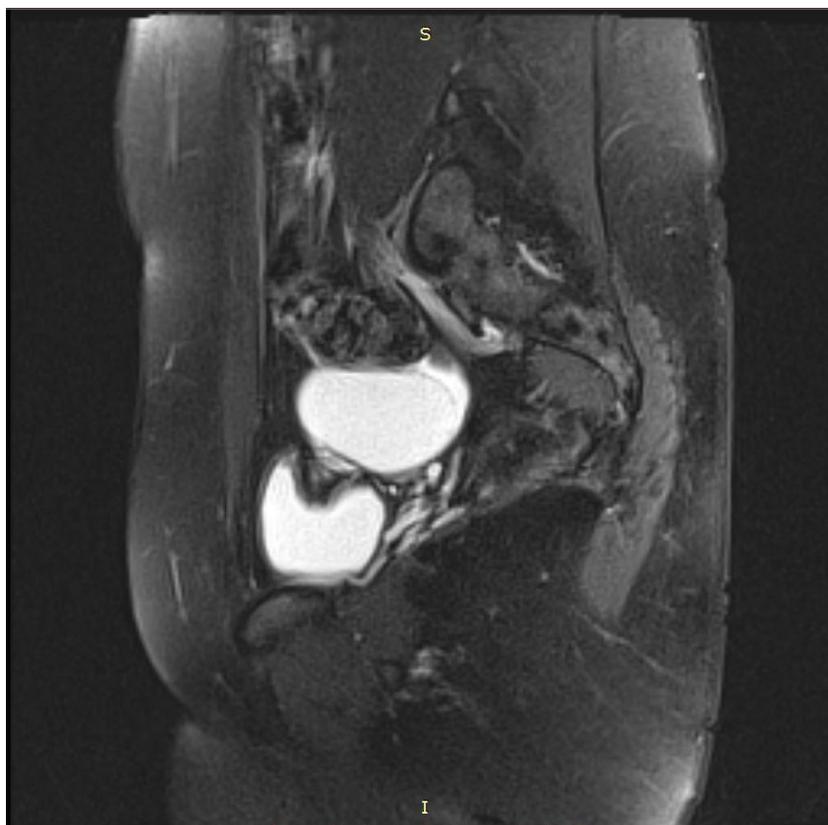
Ovarian Cancer Magnetic Resonance Image
